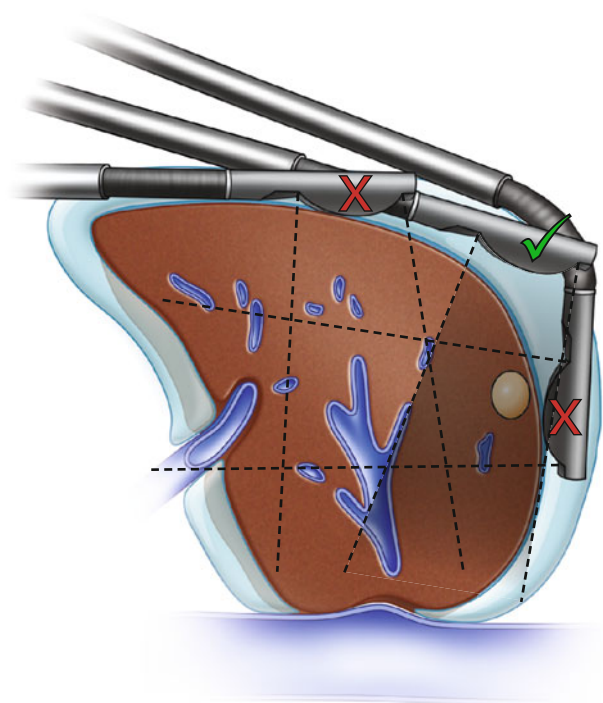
The standoff technique used to visualize a superficial lesion high on the dome of the liver, which would be difficult to access directly with the ultrasound probe. This allows the lesion to be visualized through both the liver tissue and water layer with a clear image on-screen. The inferior (*red X, top*) probe position is the farthest a straight probe can achieve while maintaining contact directly with the liver tissue. The lesion is missed. The superior (*red X, right*) probe position requires the probe to be flexed around the edge of the liver to visualize the tumor, making targeting extremely difficult. The middle (*green check mark*) probe position allows the surgeon to visualize the tumor with a straight probe, making targeting for ablation most straightforward
